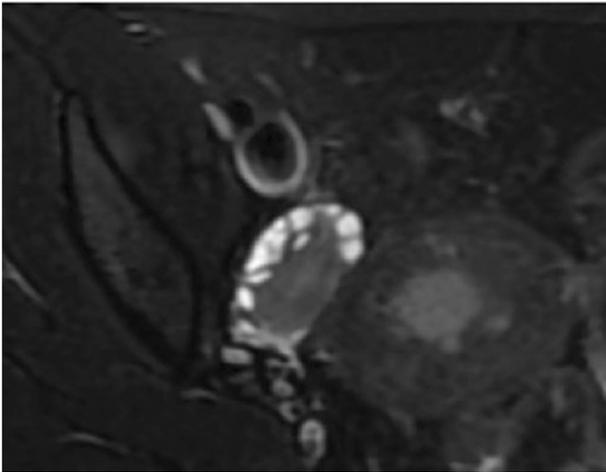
Axial T2-weighted MR image from another patient who has been clinically diagnosed with PCOS shows a similar distinctive follicle morphology of the right ovary. (Image courtesy of Avisha Singla, MD, of the Kempegowda Institute of Medical Sciences)
